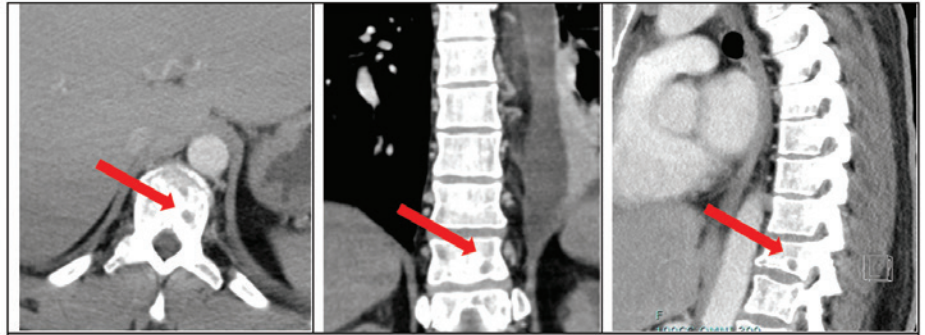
CT chest (axial, coronal, and sagittal views) showing lytic lesion. CT chest showing bony lesion on T11 vertebral body (shown with red arrow).
